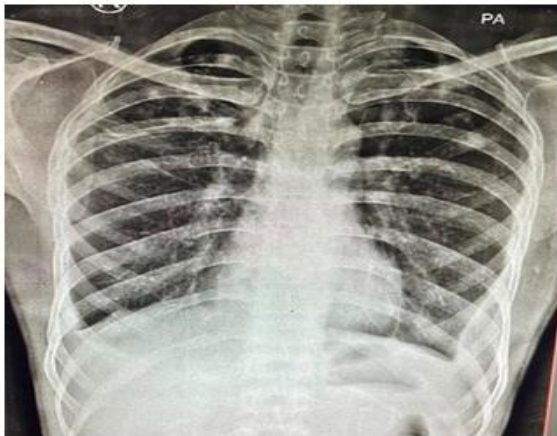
Chest x-ray PA view at the end of six months of antitubercular treatment showing persistent left sided loculated pleural effusion in the patient.
